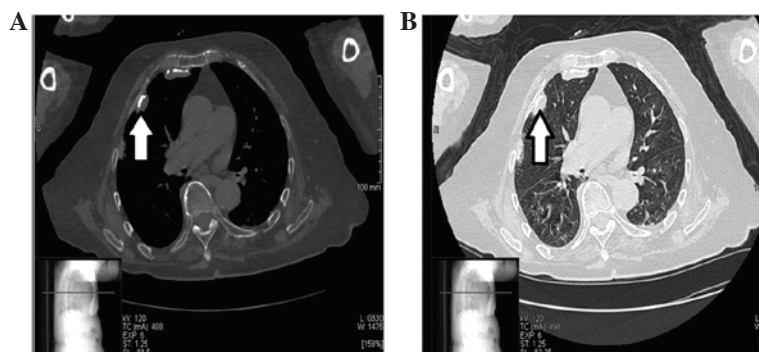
High-resolution computed tomography imaging demonstrated partially calcified pleural plaques in the left parietal pleura (arrow). (A) View of the mediastinum, (B) view of the parenchyma.
